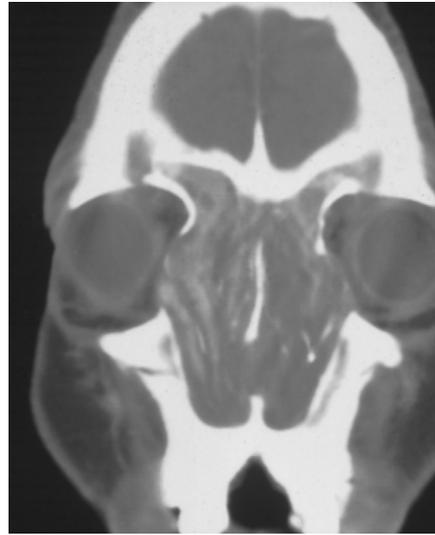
Coronal CT image of a patient with bilateral aspergilloma with extension into the orbits.
